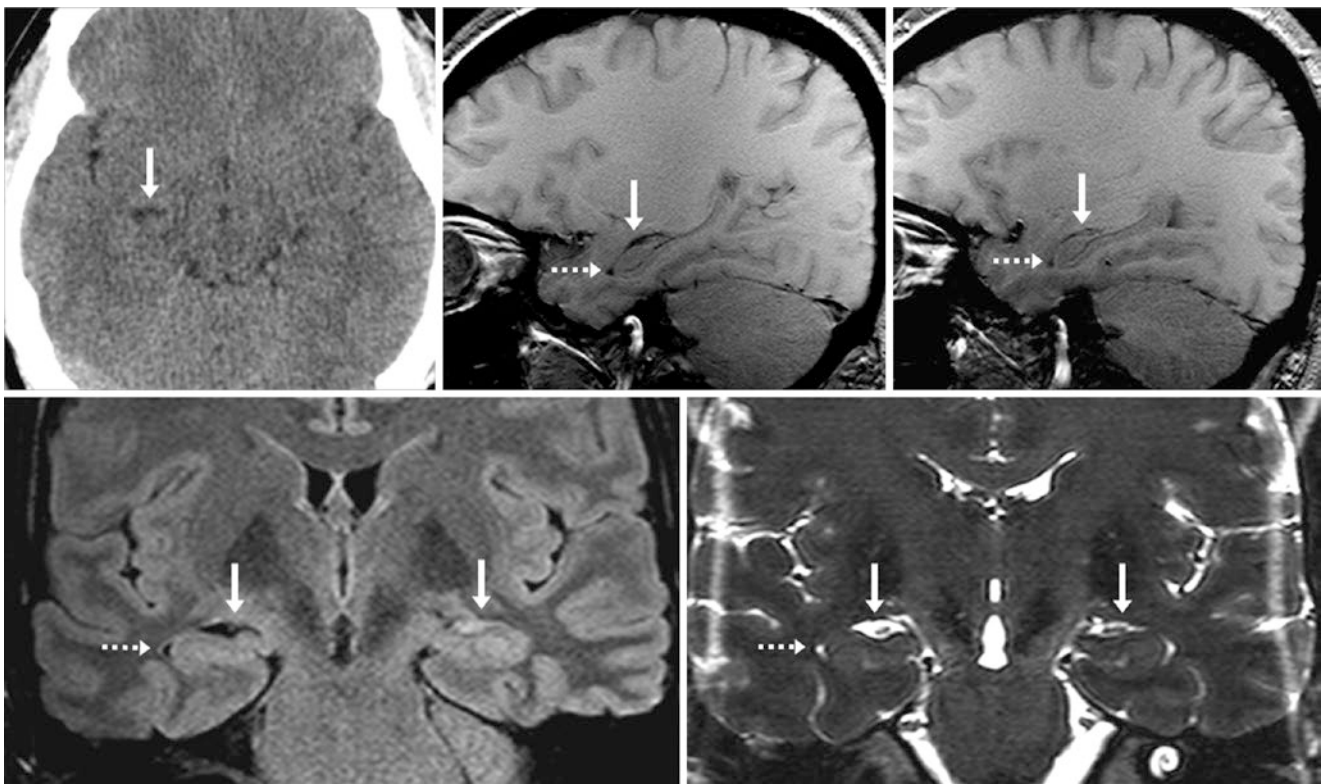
A 31 year old had an axial NECT (*top left*) depicting prominence of the right choroidal fissure (*arrows*) near the temporal horn's anterior tip (*dashed arrows*), better seen on a 3 T MRI with sagittal T1WI of the right (*top middle*), as compared to the left side (*top*
